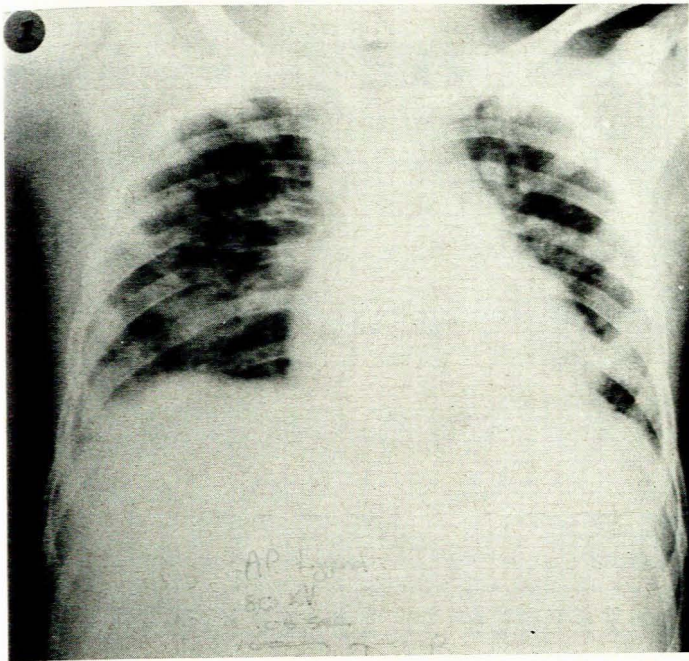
Case 2. Radiographs on admission (top) and discharge (bottom) from Unit. Pneumatocele visible in right lower lobe on discharge.
